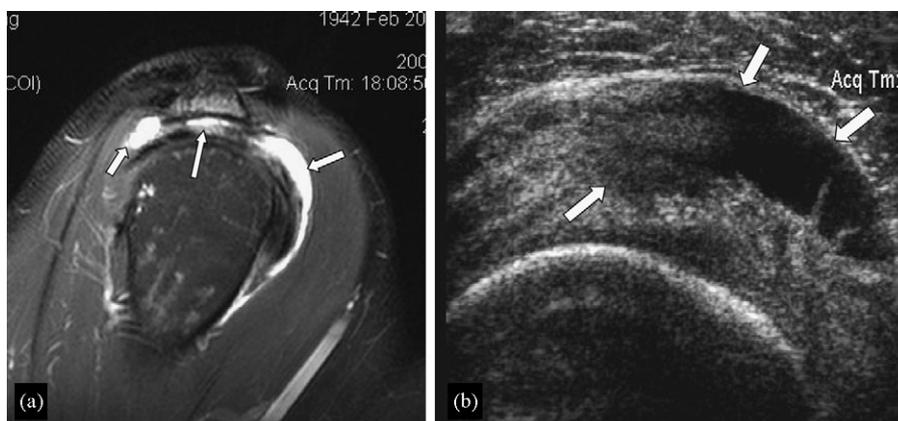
A 64-year-old male patient with clinically suspected rotator cuff pathology. (a) The fat suppressed T2-w TSE oblique sagittal MR image shows high signal intensity and fraying involving the bursal side of the supraspinatus tendon (long arrow) and high signal intensity fluid inside the bursa itself (arrows), in keeping with a bursal surface partial-thickness tear. (b) The longitudinal sonogram shows to better advantage an anechoic area involving the bursal surface of the supraspinatus tendon (arrows).
